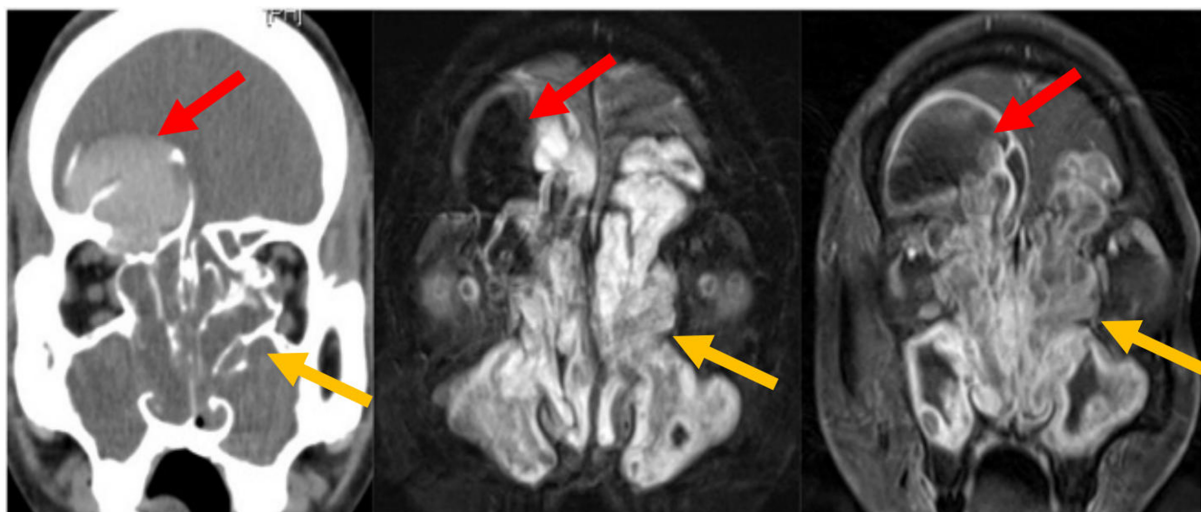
Coronal CT and MRI images of a right frontal sinus mucocoele and sinonasal polyposis. The right frontal sinus is airless and expanded. Hyperdense secretions on CT correspond to the signal void on MRI (red arrows). Bony deficiency surrounds the mucocoele. Polyps show low CT attenuation and characteristic T2 hyperintensity with peripheral enhancement on MR (yellow arrows). CT: Computed tomography; MRI: magnetic resonance imaging; MR: magnetic resonance.
